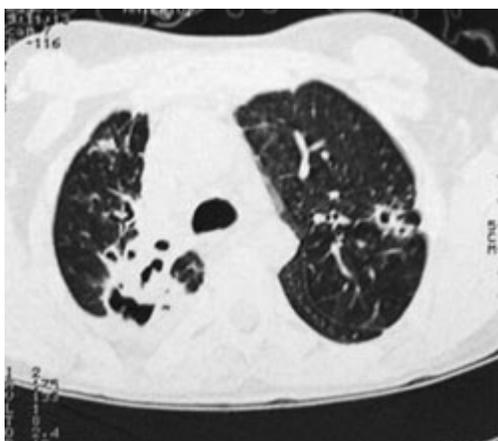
CT image of post kochs apical lung fibrosis in patient who presented with vocal fold paralysis.
